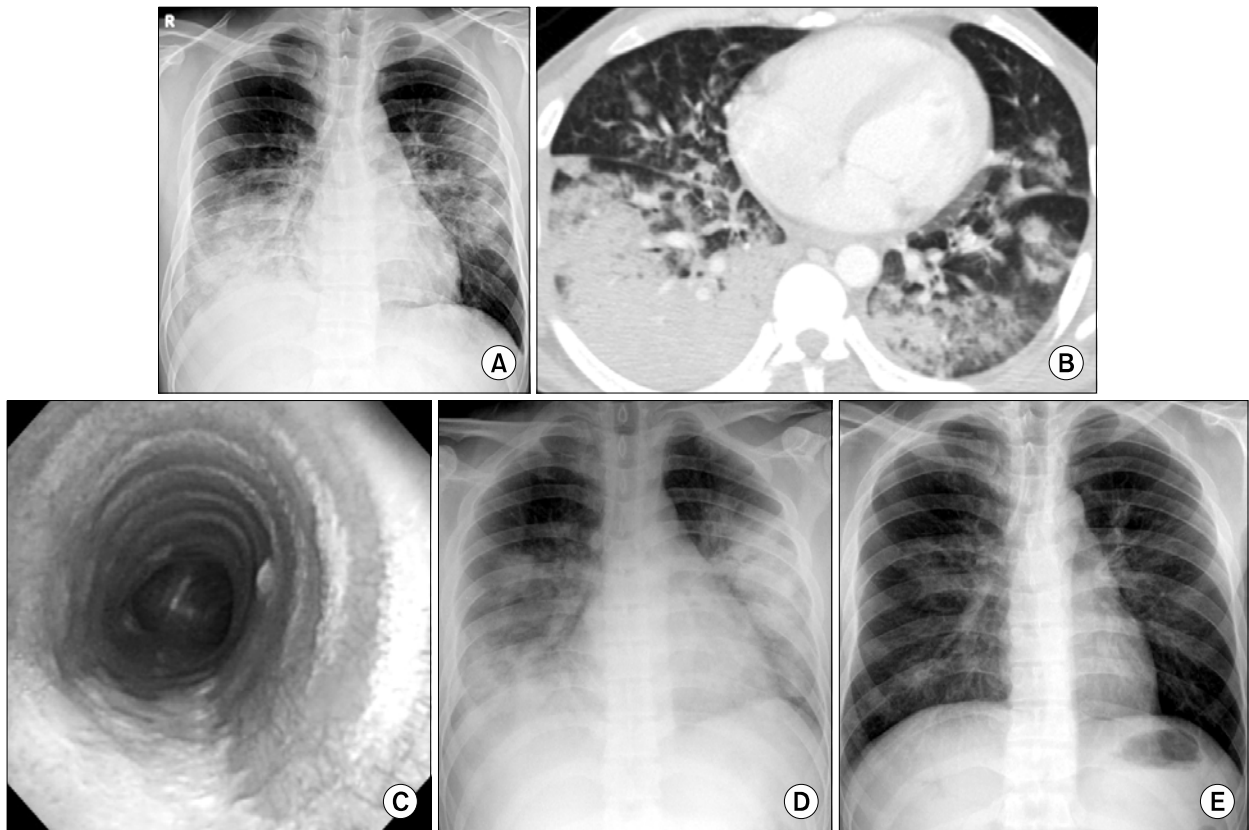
A 29-year-old man with *M. pneumoniae* pneumonia. Chest radiograph at admission reveals bilateral , patch and lobar consolidation in right lower and left upper lung field (A). Chest CT scan shows multi-focal lobar consolidation, mainly in right lower lobe, with pleural effusion (B). Fiberoptic bronchoscopy shows ulcerative lesion covered with necrotic exudation on the posterior wall of trachea (C). Follow up chest radiograph, 3days later, shows more aggravated consolidation (D). Follow up chest radiograph, 13 days later, shows improved state (E).
